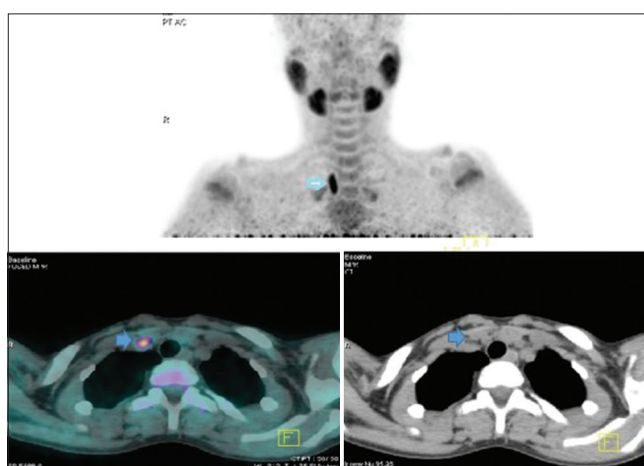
The same patient as in Figure 1, also showing concordant localization on <sup>18</sup>F-FCH PET/CT. PET/CT: Positron emission tomography/computed tomography, FCH: Fluorocholine
